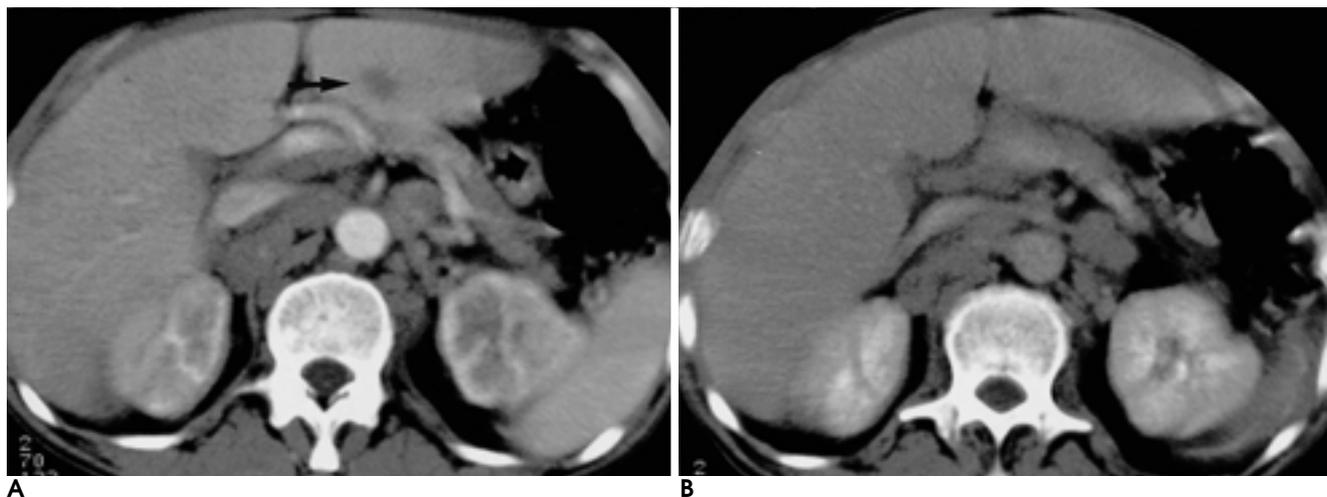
Secondary Hodgkin 's disease in a 60-year-old man. Early phase CT (A) shows about 2cm sized ill-defined low attenuation mass (arrow) in segment 3 of liver and associated multiple lymph node enlargements in paraaortic and aortocaval area. Late phase CT (B) shows centripetally enhanced mass.
